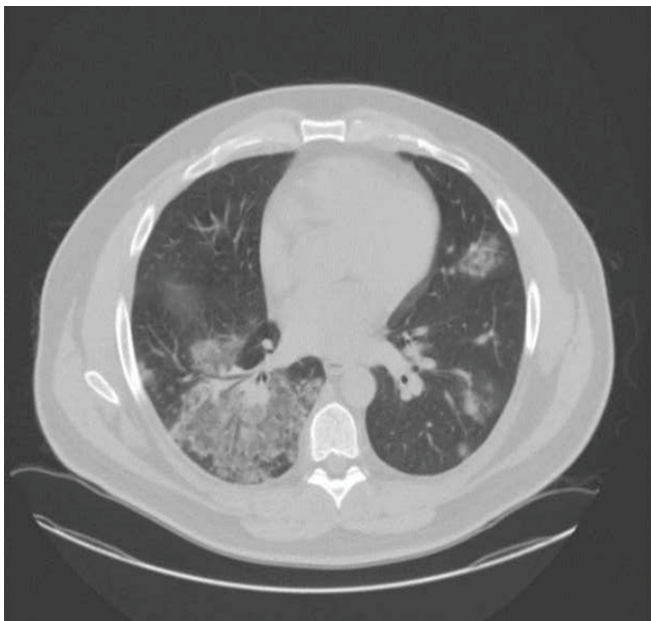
CT scan of the chest demonstrating additional radiographic changes typical for both COVID-19 and M. pneumoniae.
